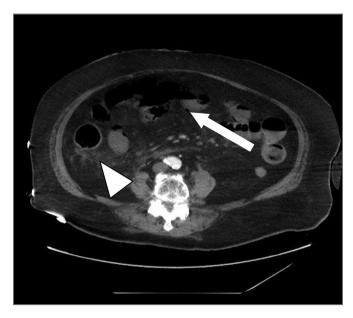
CT scan of the large intestines shows thickened wall with gas (arrow) and pericolic adipose tissue infiltration (arrowhead).
